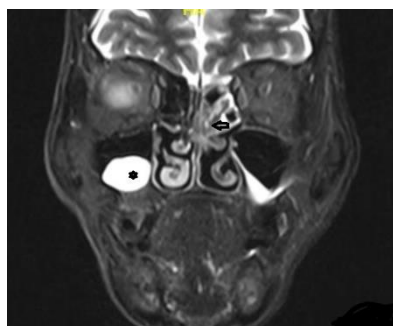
Pre-operative MRI T2 weighted image in coronal view depicting the tumour as an intense intermediate mass. The black arrow shows the mass. The black star represents an incidentally detected mucus retention cyst in the right maxillary sinus.
